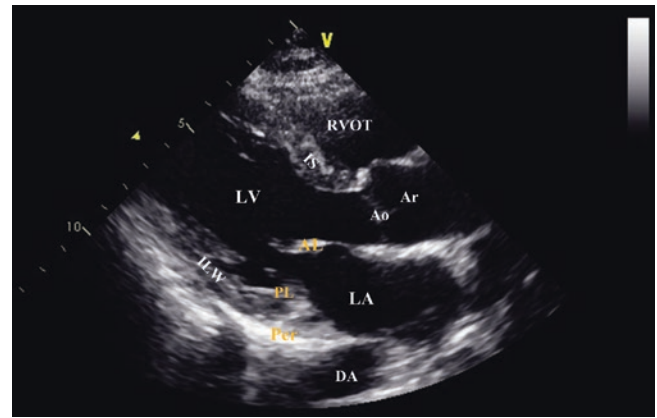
Parasternal long axis view. This view allows visualization of the right ventricular outflow tract (RVOT), left atrium (LA) and left ventricle (LV). The interventricular septum (IS) and the inferolateral wall (ILW) of the left ventricle are also seen. Bright pericardium (Per) is seen behind the left ventricle. This view also allows identification of the aortic valve (Ao) and aortic root (Ar), anterior (AL) and posterior (PL) leaflets of the mitral valve, and descending aorta (DA). Color Doppler examination in this view allows visualization of mitral regurgitation and aortic regurgitation. See also Video 16.1
